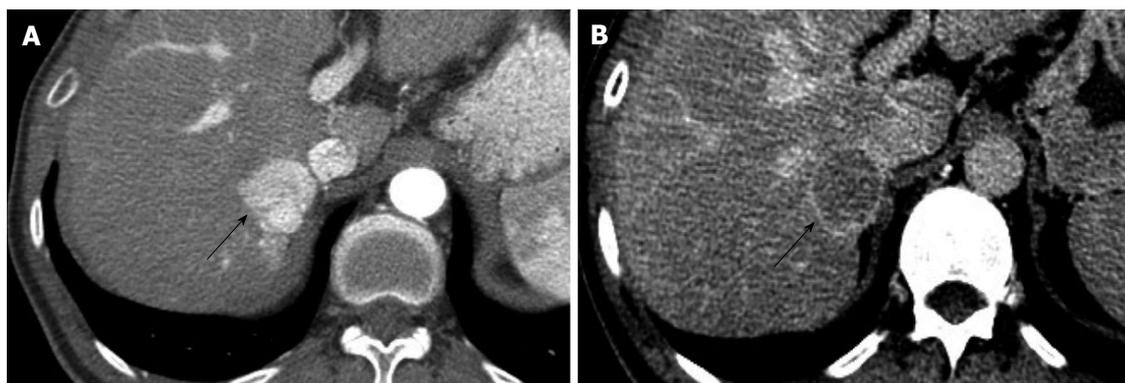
Computed tomography of hepatocellular carcinoma in 48-year-old male with hepatitis C. A: Arterial phase contrast enhanced CT of the liver shows a strongly enhancing mass (arrow) in the right lobe, adjacent to the IVC. B: The same lesion (arrow) washes-out of contrast on the delayed phase and shows a thin capsule, this is diagnostic for HCC and corresponds to LI-RADS category 5. HCC: Hepatocellular carcinoma; CT: Computed tomography; LI-RADS: Liver imaging reporting and data system; IVC: Inferior vena cava.
